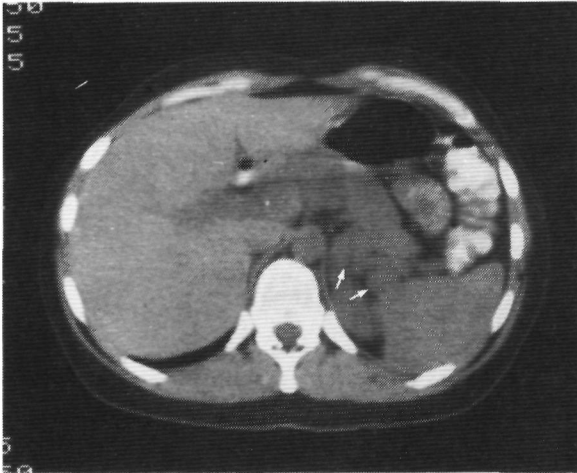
Female patient of 34 years with HD, mixed cellular type. CT scan originally misinterpreted as showing no abnormalities. Staging laparotomy revealed an involved spleen and enlarged retropancreatic nodes, which were radiologically visible in retrospect (arrows).
